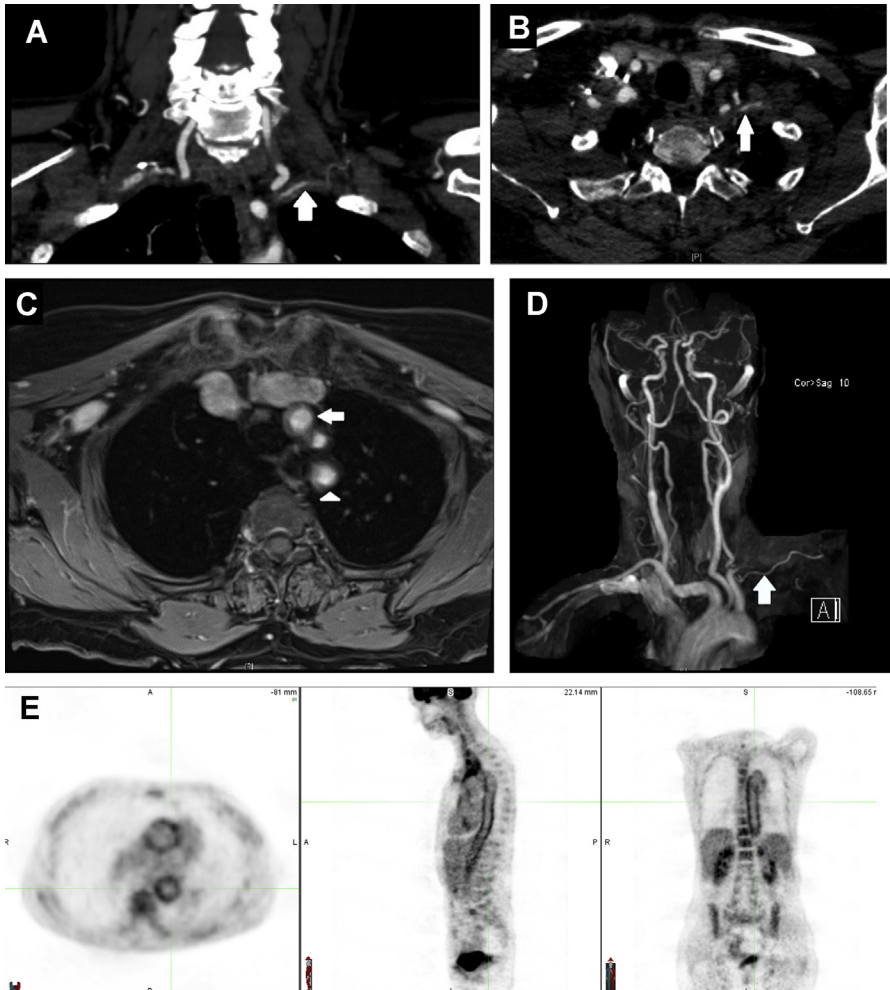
A 64-year-old woman with predominantly large vessel involvement. CTA with and without contrast showing abrupt occlusion of the left subclavian artery (arrow in A and B). High-resolution MRI of the head and neck with and without contrast demonstrates mural thickening and contrast enhancement of the left brachiocephalic artery (arrow in C) and left subclavian artery (arrowhead in C). Left subclavian artery vessel wall occlusion with collateral formation (arrow in D). (E) Thoracic and abdominal aortitis in a separate patient as imaged by PET/CT.
